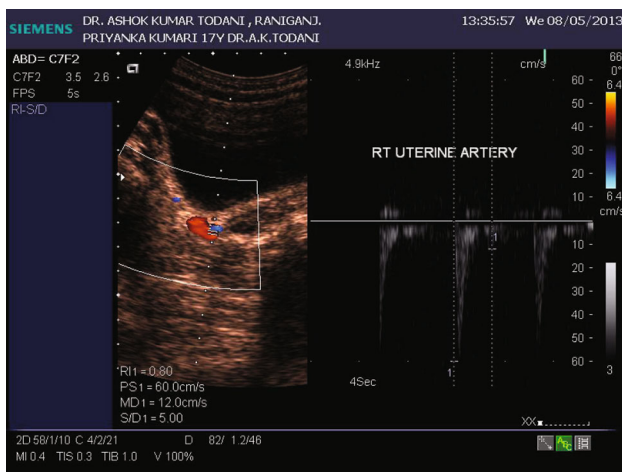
Colour Doppler of right uterine artery
